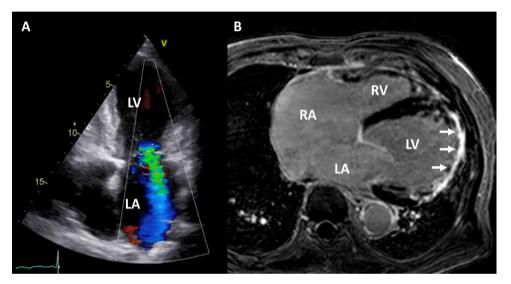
Late gadolinium contrast-enhanced cardiovascular magnetic resonance in patient with ischemic mitral regurgitation. Panel a shows the apical four-chamber view with severe mitral regurgitation based on color flow Doppler data. On late gadolinium contrast-enhanced cardiovascular magnetic resonance, the presence of myocardial scar extent can be assessed (arrows).
